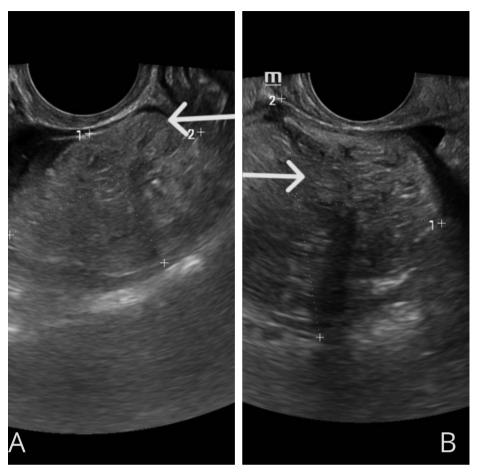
Imaging of the pelvic region using ultrasound - Arrows point out the ovary and a mass in the ovary.
